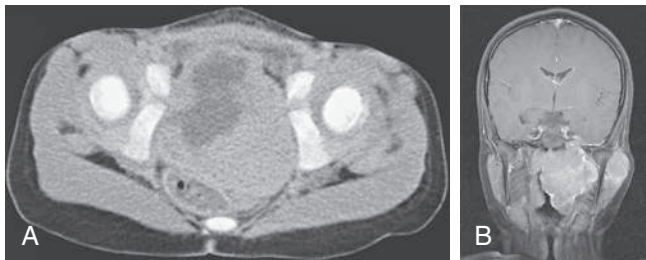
A, Pelvic CT scan of a child with a bladder rhabdomyosarcoma. B, MR image of a child with a parameningeal rhabdomyosarcoma.
